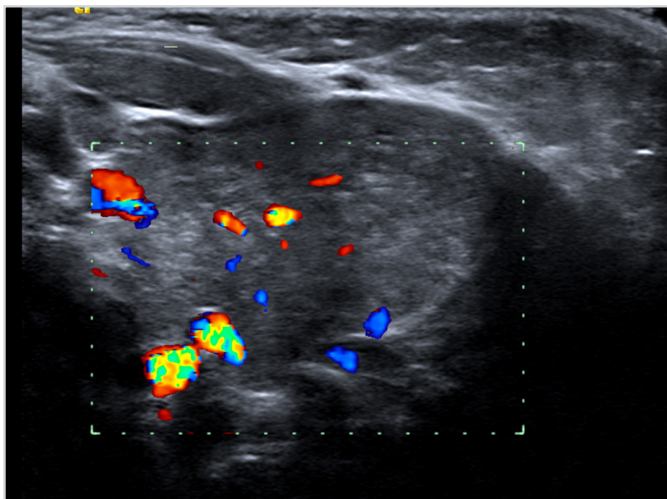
Doppler ultrasonography image of ECT showing the vascularization of the tissue
